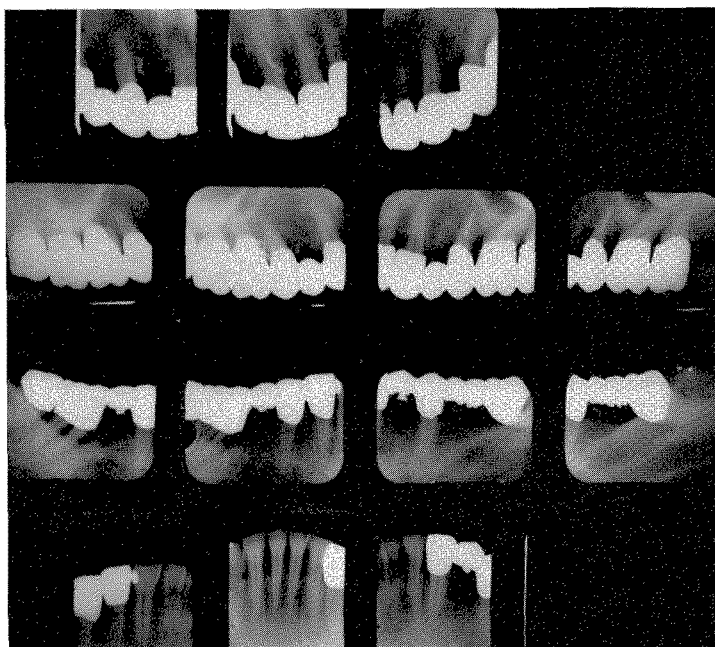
Roentgenograms at the completion of treatment, December, 1954.
